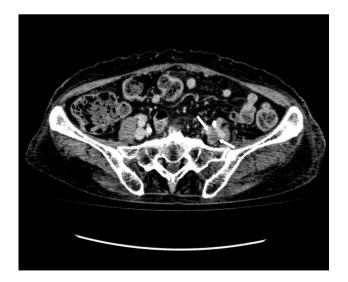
Multidetector CT venography showed a typical filling defect in the left iliac vein of this 80-year-old female; this patient had leftside total hip arthroplasty. A thrombus is visible in the left iliac vein (*white arrows*)
